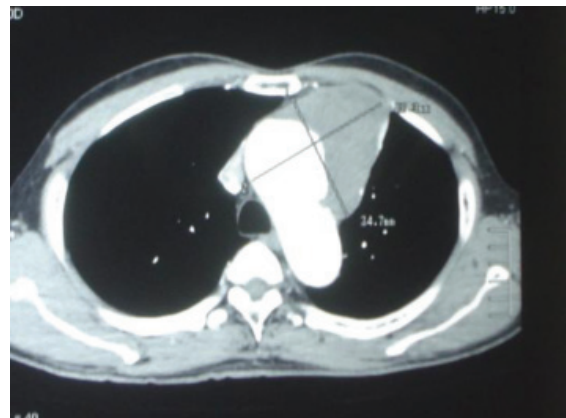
Computed tomography scan showed a large saccular aortic arch aneurysm which eroded into the chest wall.
